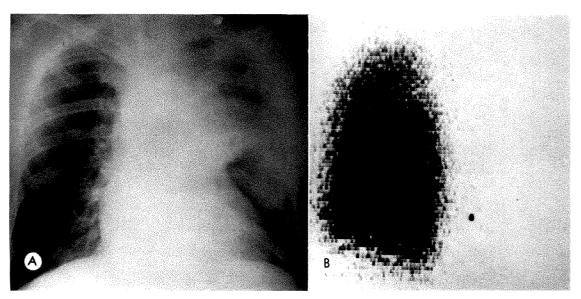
Bronchogenic Carcinoma Arising in Left Hilus. (A) Chest roentgenogram discloses a large hilar mass with obstructive features. However, aeration of the lung elsewhere appears normal. (B) The lung scan reveals total ischemia of the left lung. See also Figure 5, patient OS.
